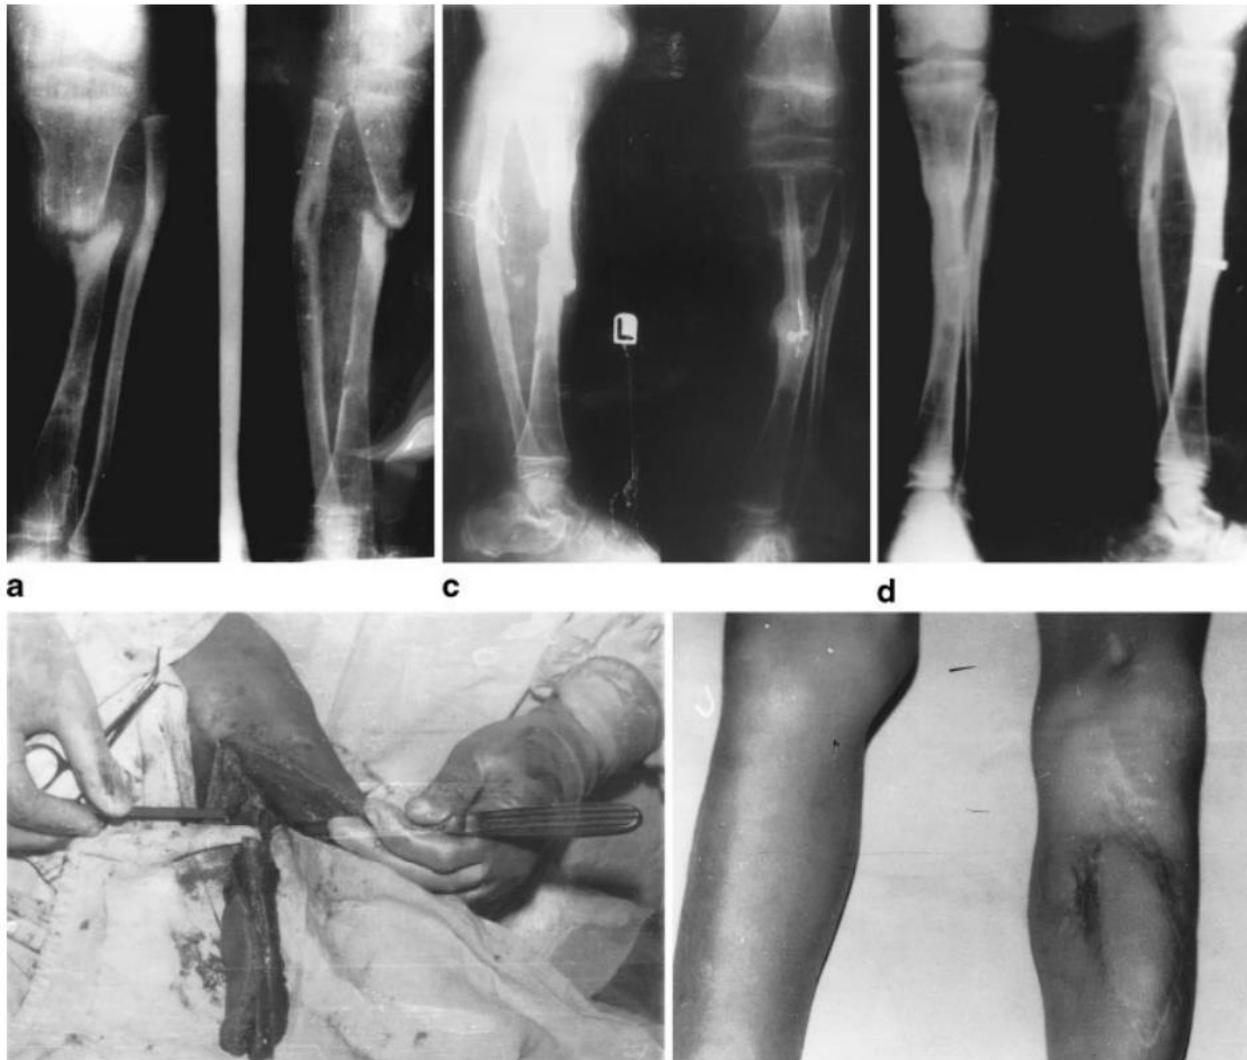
the preoperative radiograph of nonunion tibia fractured, and after debridement with defect smaller than 6cm. C showed radiograph 11 months post-operative, the E skin island after 2 years.
